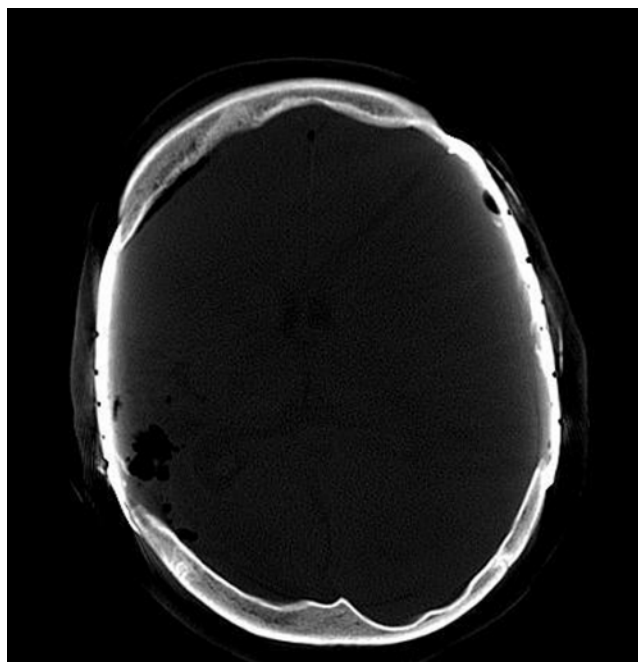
Axial CT scan obtained in a 13-year-old girl with the history of a severe head injury and subsequent bilateral osteolysis with the need of bilateral alloplastic cranioplasty.
